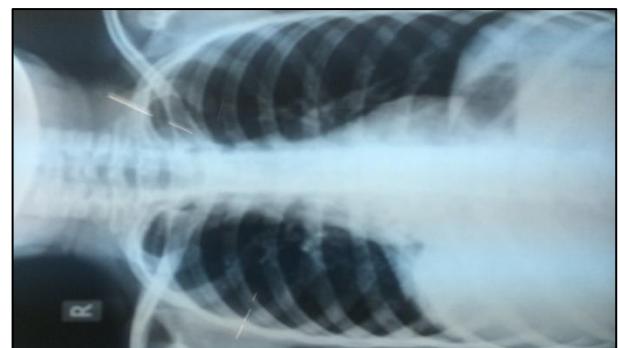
(B): Chest X-ray of resolution of consolidation with amphotericin treatment.
